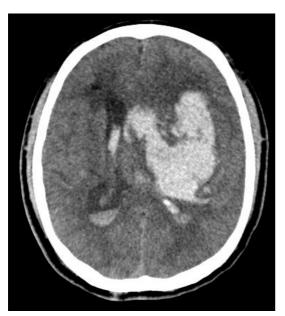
Computed tomographic scan of brain revealed a large intracerebral hemorrhage over left basal ganglia with ventricular extension. There was the mass effect with midline shift.
